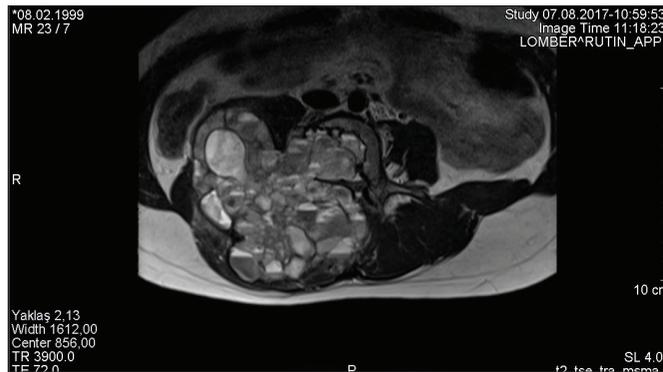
Hyperintense MRI image showing fluid-fluid level at the L4 vertebra's right half on T2 axial images.
